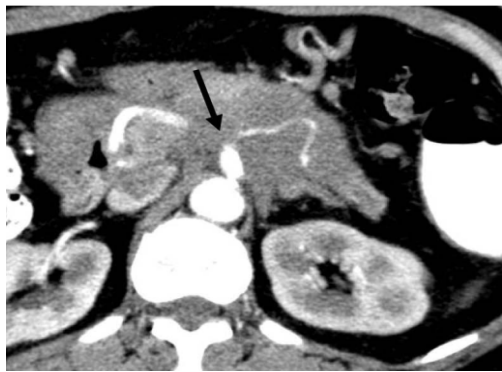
(a) CT scan of a 54-year-old patient with diagnosis of moderately-differentiated pancreatic adenocarcinoma demonstrates intrahepatic duct dilatation in both hepatic lobes (arrowheads). There is an ill-defined soft tissue density invading and causing pressure effect to posterior aspect of deformed right main portal vein (arrowed), representing hepatoduodenal ligament and portal vein involvement. (b) CT scan of the same patient reveals an ill-defined pancreatic mass encasing gastroduodenal artery (arrowed), representing GDA involvement.
